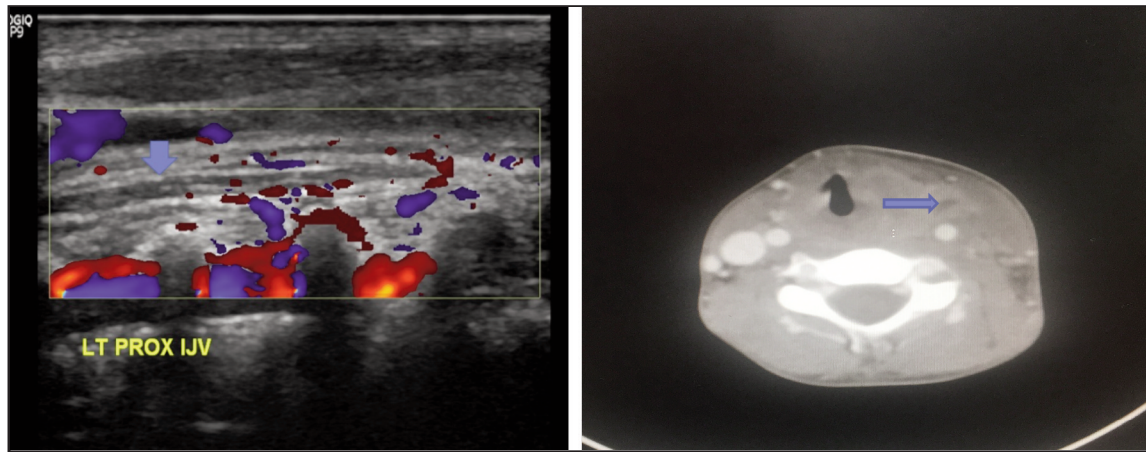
(a), (b): Short segment IJV thrombosis (blue arrow) noted on the ultrasound doppler of neck. CT scan of neck (axial view) demonstrating a partially occlusive thrombus in the left internal jugular vein (blue arrow) with diffuse soft tissue thickening.
